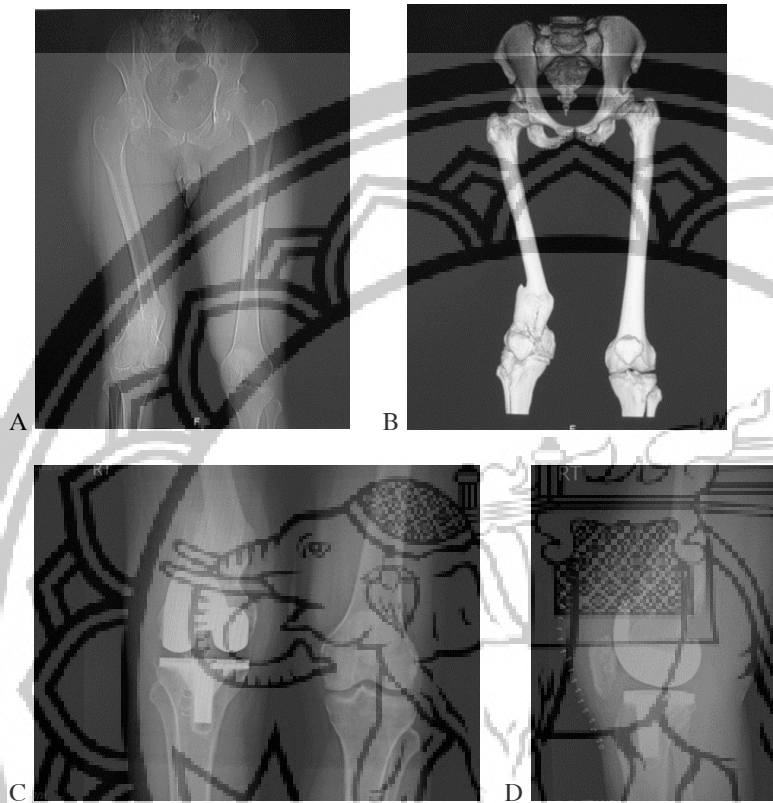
TKA combining with intra-articular correction technique (Preoperative radiograph (A) and 3-D CT scan (B) of patient with extra-articular deformity of right femur. After treated by TKA combining with intra-articular correction technique (C, D).)
